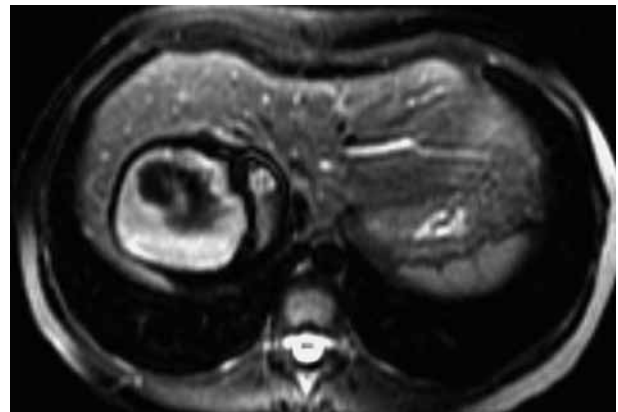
Axial fat saturation T2-weighted MR image : the fatty component had decreased in signal intensity like the subcutaneous macroscopic fat.
